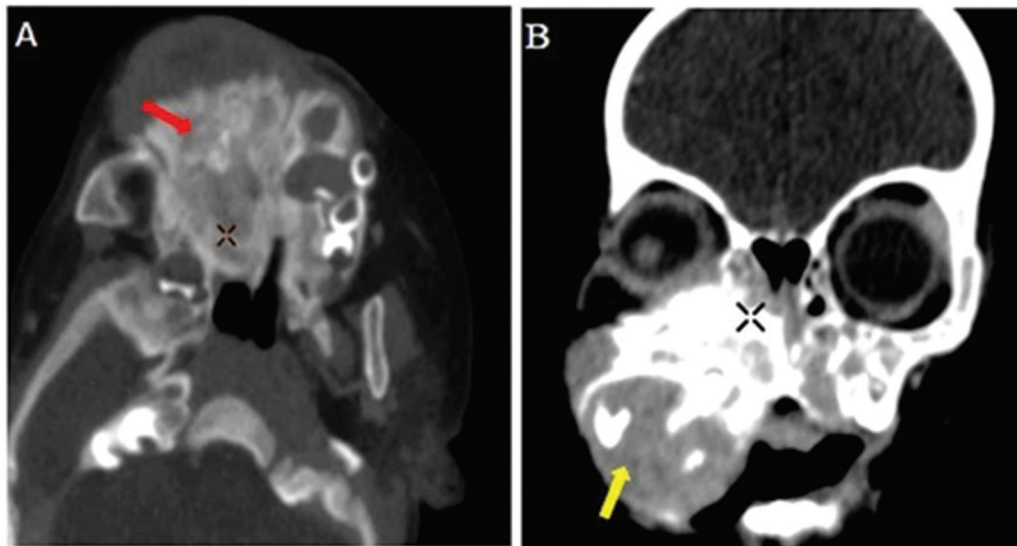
(A) Axial computed tomography (CT; bone window) shows expansile sclerotic mass (red arrow) involving bilateral maxillary bones with nasal extension. (B) Coronal reformatted CT image shows expansile mass involving the maxillary bone right > left, with accompanying exophytic enhancing soft tissue (yellow arrow).
